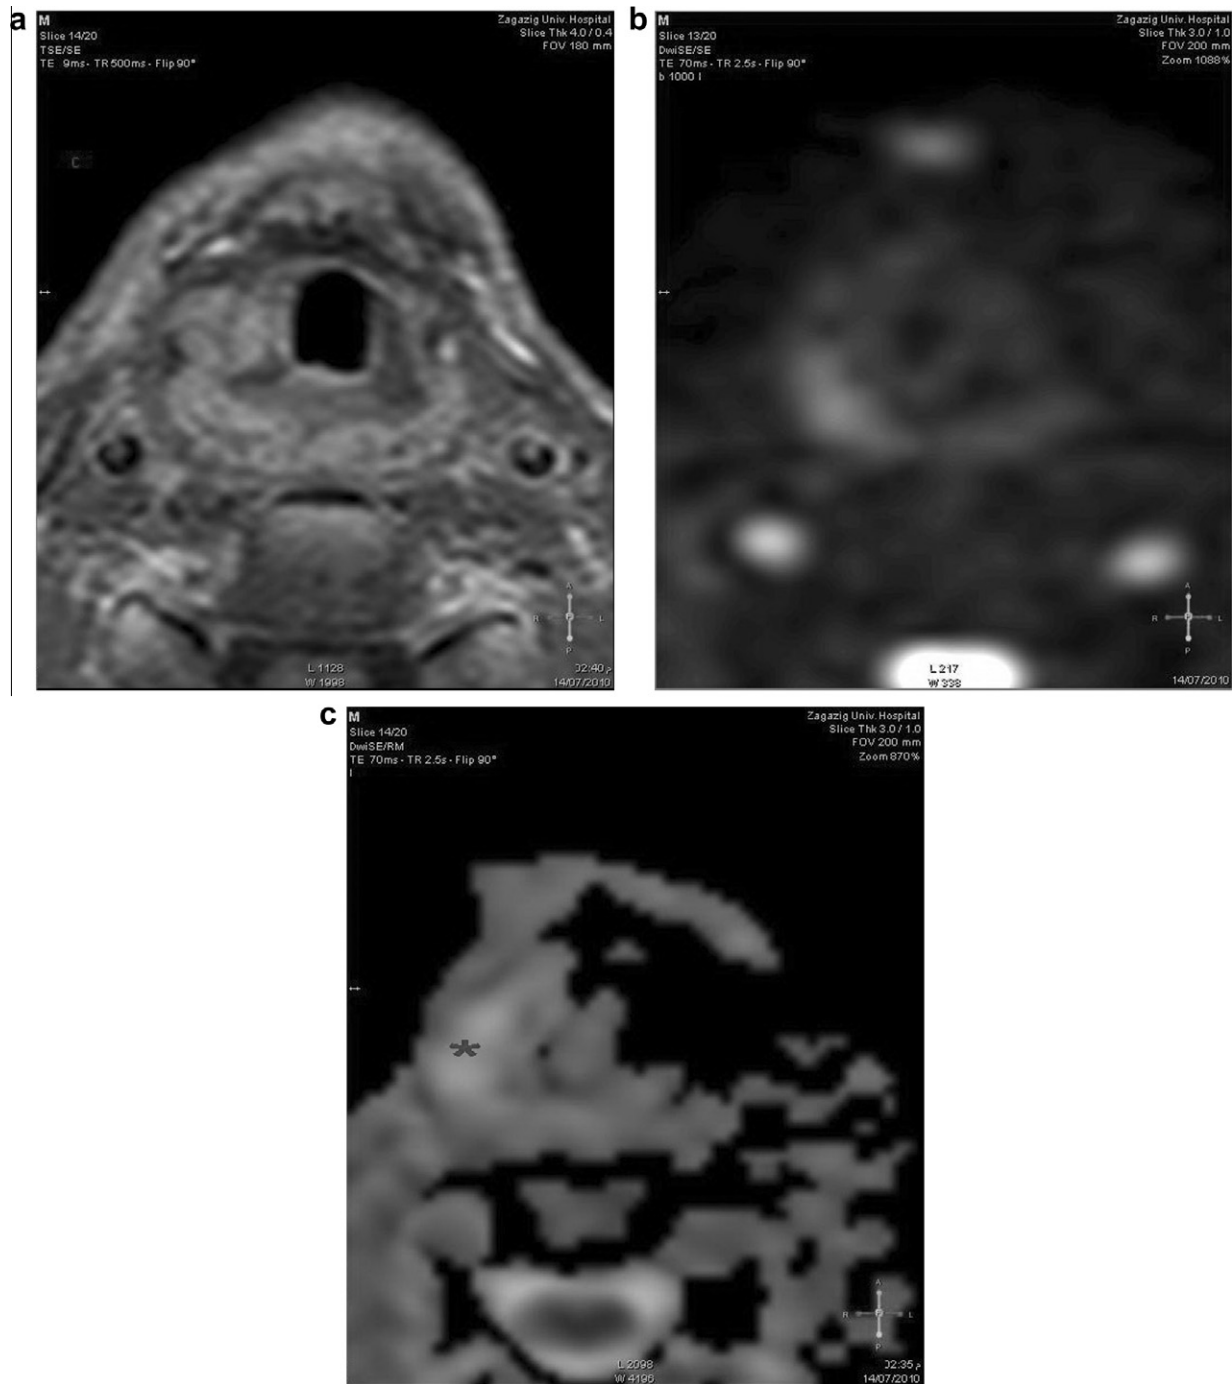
Axial contrast enhanced T1 weighted MR image (a) shows heterogeneously enhancement lesion at the infraglottic laryngeal region. No significant asymmetrical hyperintensity can be detected by DWI b 1000 (b). ADC map (c) shows hyperintensity (*) at the same site of the lesion. The lesion was pathologically proved to be inflammatory changes with no tumor recurrence.
